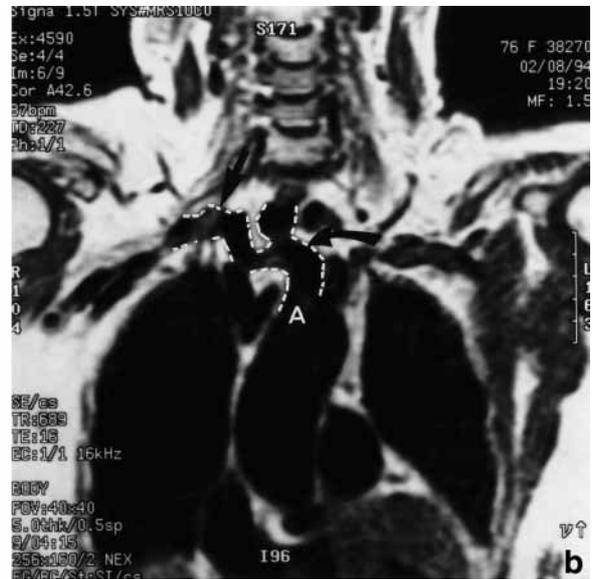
MRI scan of a patient showing dilatation of the proximal subclavian artery (straight black arrow). The second portion of the brachiocephalic artery appears tortuous (curved black arrow), looping into the base of the neck. The patient presented with a pulsate swelling in the base of the neck. A—ascending aorta.
